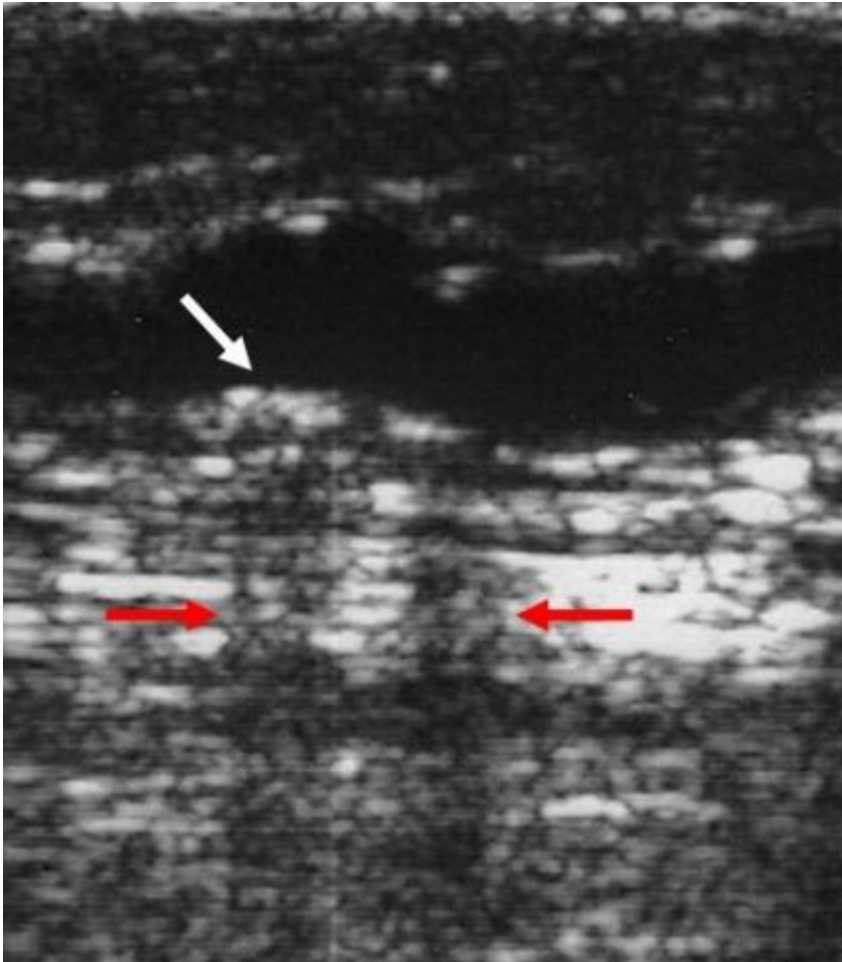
An ultrasound image of calcification in the saphenous vein wall. The white arrow is indicated the calcification in the vein wall. The red arrows indicate the acoustic shadowing produced by the calcification.
